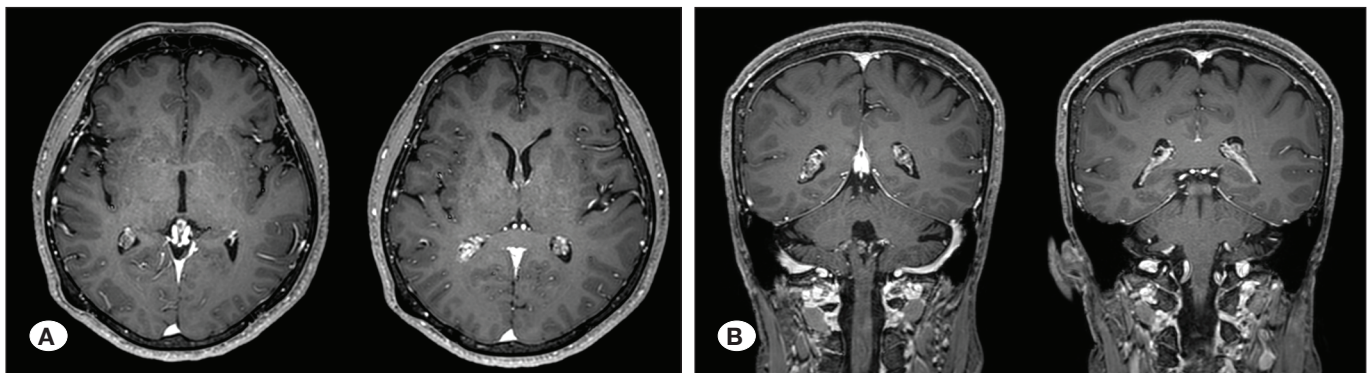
Follow-up axial (A) and coronal (B) cranial magnetic resonance images performed 2 years later showing a complete disappearance of the bilateral choroid plexus cysts in the trigone of the lateral ventricles.
